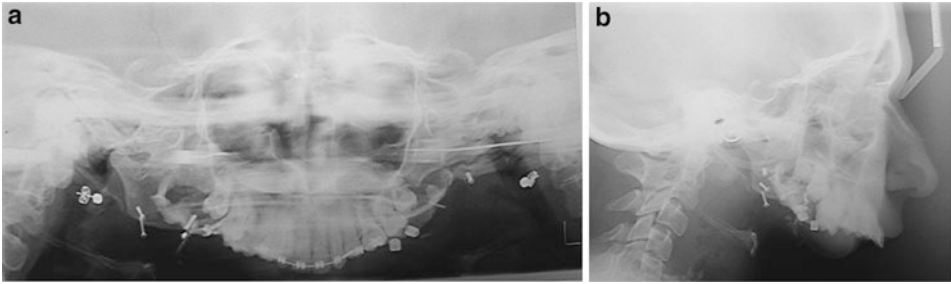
(a, b) Radiographs of orofacial structures showed absence of mandible
